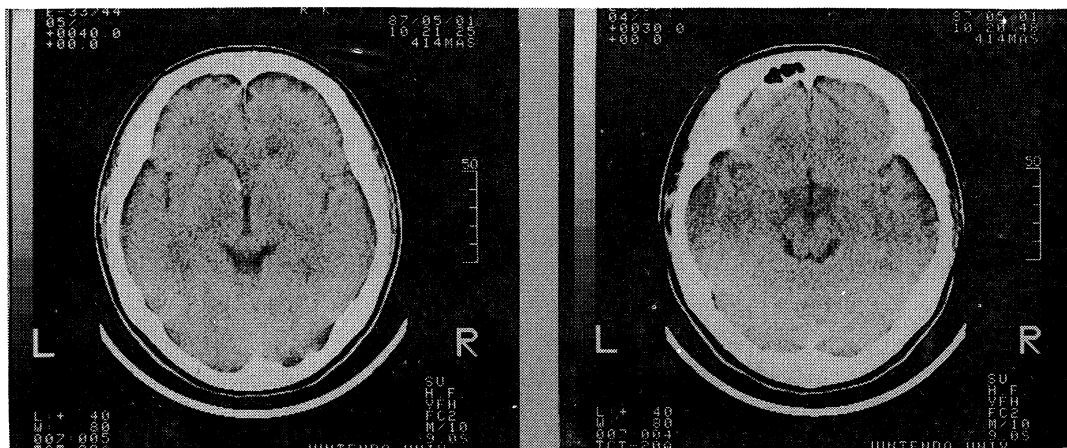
CT scans of Case R.K. showing a tubercle located in the anterior of the ventricle.
